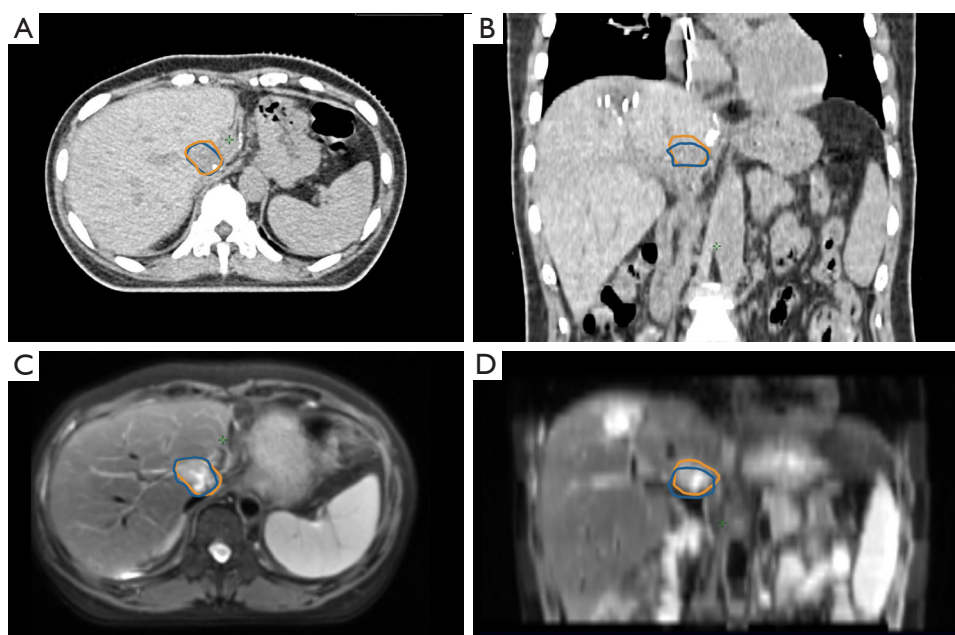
An example of comparison of tumor contours generated from 4D-CT and 4D-MRI. The orange outline is the contour from 4D-MRI and the blue outline is the contour from 4D-CT. (A,B) The CT images in the axial and coronal views; (C,D) the MRI images in the axial and coronal views. 4D, four-dimensional; CT, computed tomography; MRI, magnetic resonance imaging.
